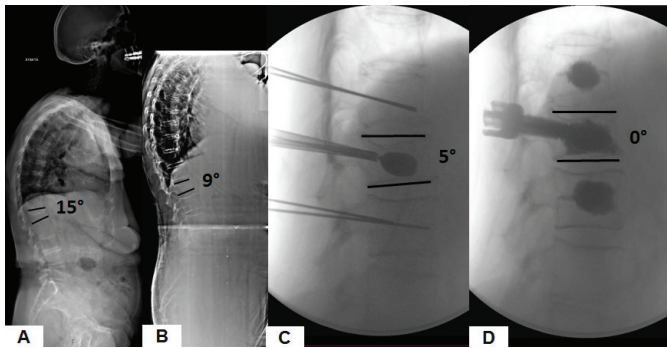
Preoperative standing lateral X-ray evaluation A) and lateral X-ray evaluation, B) taken in a prone position over Jackson table (Mizuho OSI) demonstrating an unstable fracture of L1 osteoporotic vertebra fracture with a vertebral body angle improving from 15° to 9°. C) Intraoperative lateral fluoroscopic evaluation demonstrating kyphosis reduction using balloon inflation at L1 fracture and transpedicular placements of cannulas to the adjacent levels (T12 and L2 vertebrae) for prophylactic vertebroplasty preparation. The balloon inflation improved the vertebral kyphosis from 9° B to 5° C. D) Intraoperative lateral fluoroscopic evaluation demonstrating vertebroplasty combined with bilateral transpedicular fixation of the fracture and prophylactic vertebroplasty at the adjacent levels. Balloon kyphoplasty restored the khyphosis to 0°
